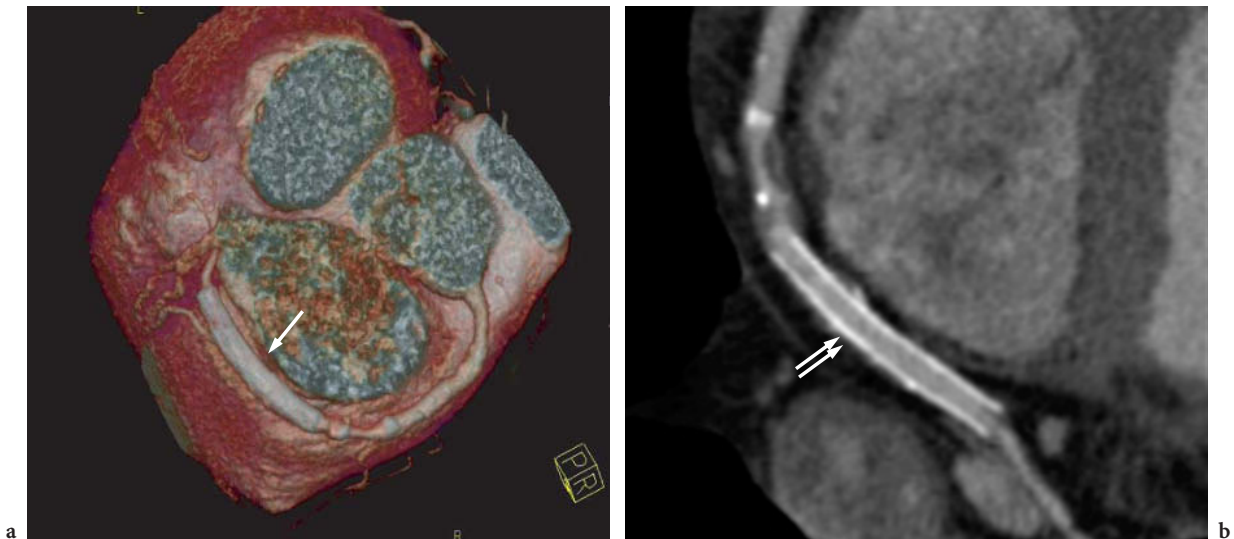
Curved MPR for a coronary artery examination obtained on a 16-slice CT scanner with 16×0.75 -mm collimation. The patent in-stent lumen of the stent in the distal RCA coronary artery can be demonstrated in VRT display (a, arrow) and is readily visualized with curved MPR reconstruction (b, double arrow). (Case courtesy of HSC Medical Center, Kuala Lumpur, Malaysia)
